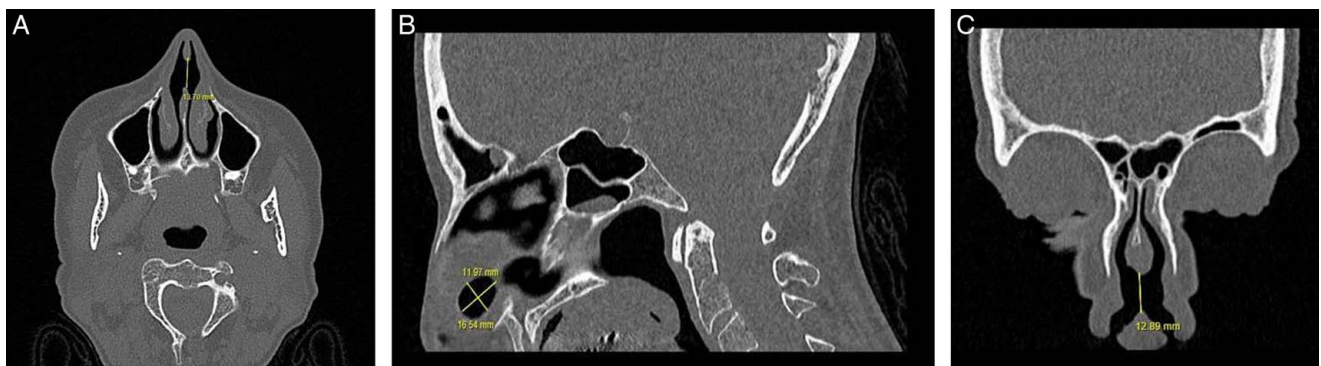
A, computed tomography (CT) scan axial cuts showing the perforation size. B, CT scan sagittal cuts showing the perforation size. C, CT scan coronal cuts, showing the perforation size.
